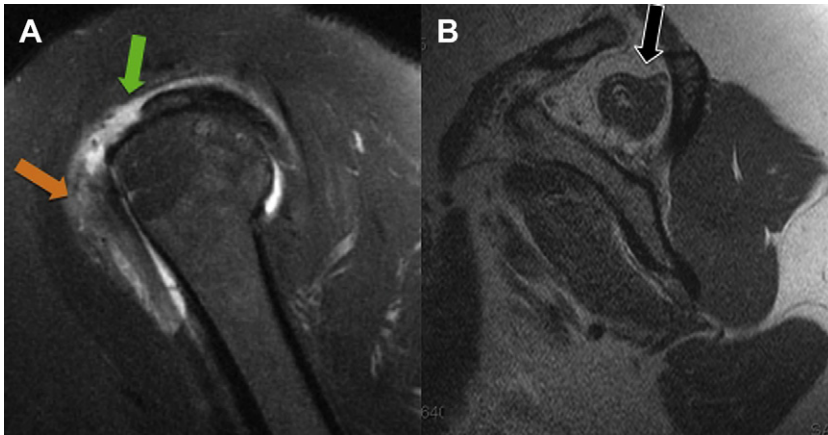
Anterosuperior rotator cuff tear. (A) Oblique sagittal fat-suppressed T2-weighted image demonstrates a full-thickness tear of the anterior supraspinatus tendon fibers (*green arrow*) extending across the rotator interval into the superior subscapularis tendon fibers (*orange arrow*). (B) There is advanced fatty degeneration and retraction of the supraspinatus muscle (*black arrow*) on this sagittal oblique T1-weighted image.
